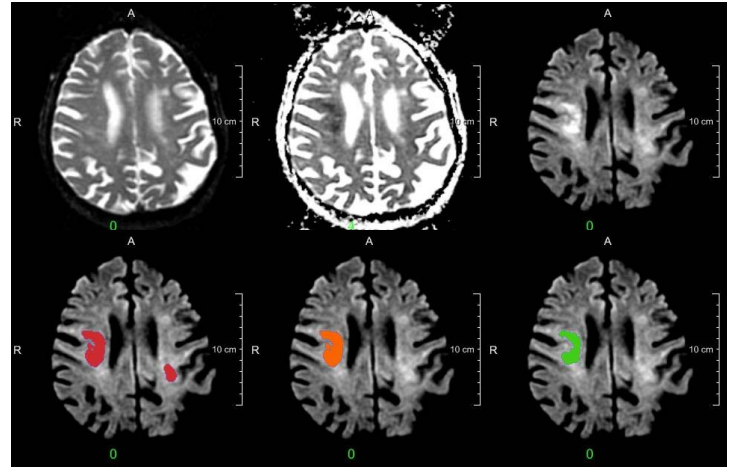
Example case with from (upper) left to right a T2WI, ADC and DWI map used as input for the method. The bottom row shows the DWI with as overlay from left to right the output from the pixel classification (red), two-stage approach (orange) and manual outline (green). Note the false detected lesion in the left hemisphere which was correctly removed by the two-stage approach.
